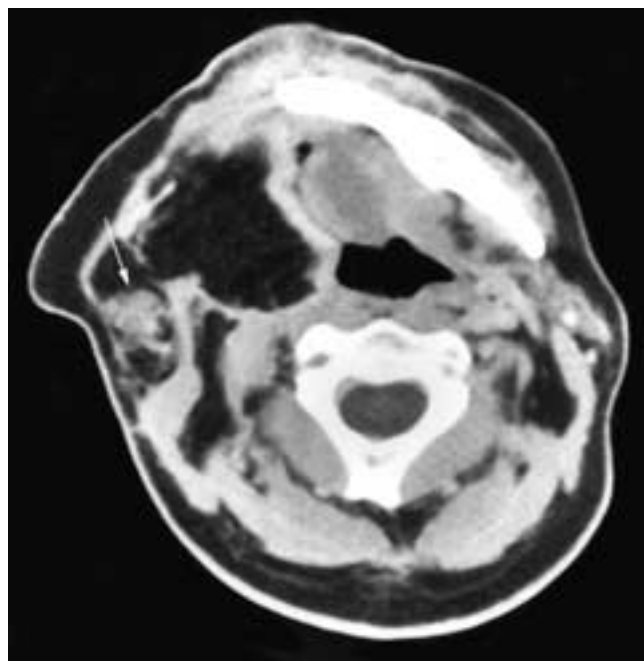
Axial contrast-enhanced CT scan on a patient who has had right mandibulectomy and a right neck dissection with a myocutaneous flap reconstruction. Within the flap, there is a nodule (*arrow*) of recurrent squamous cell carcinoma that was not clinically evident.
